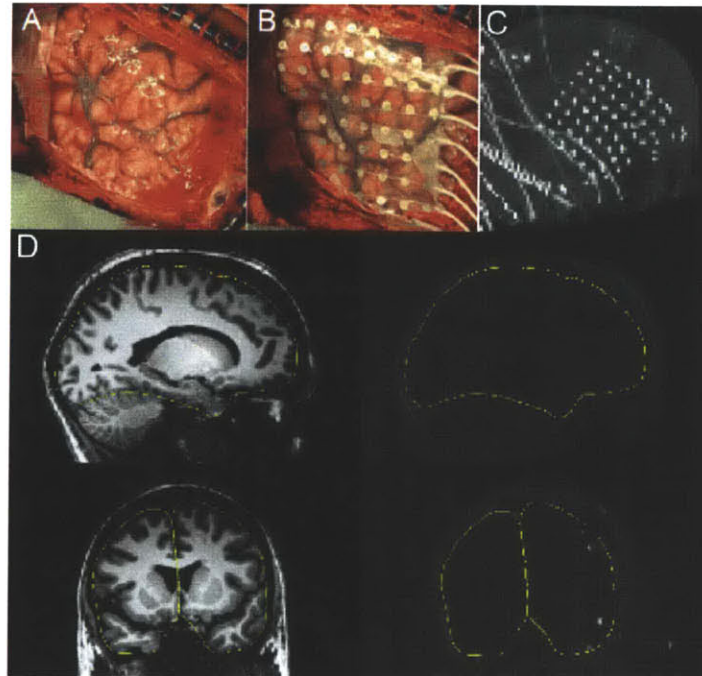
Intraoperative photographs, MRI-CT coregistration, and maximal-intensity projection.
